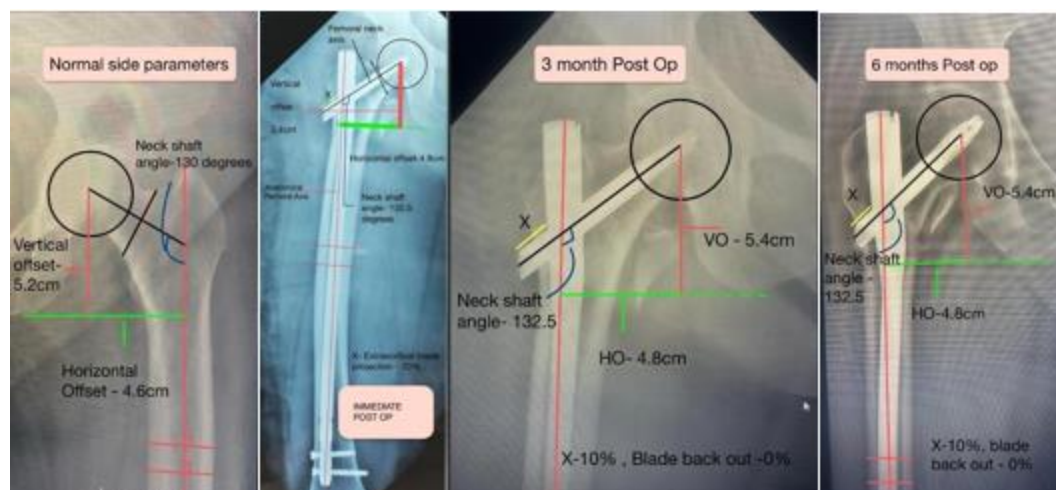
Serial radiographs showing normal side, immediate postoperative, 3-month, and 6-month follow-up images demonstrating maintenance of proximal femoral parameters after locked helical blade fixation.
